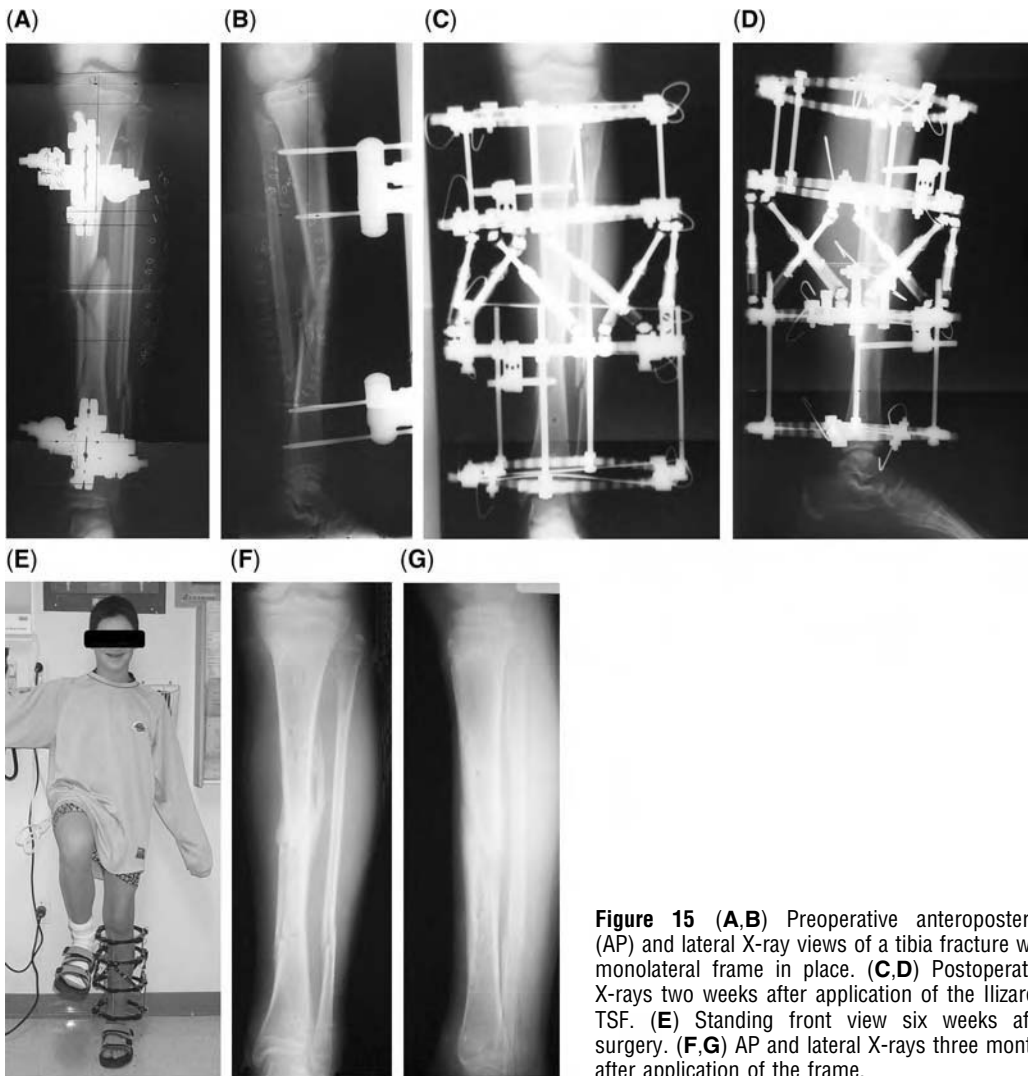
(A,B) Preoperative anteroposterior (AP) and lateral X-ray views of a tibia fracture with monolateral frame in place. (C,D) Postoperative X-rays two weeks after application of the Ilizarov/TSF. (E) Standing front view six weeks after surgery. (F,G) AP and lateral X-rays three months after application of the frame.
